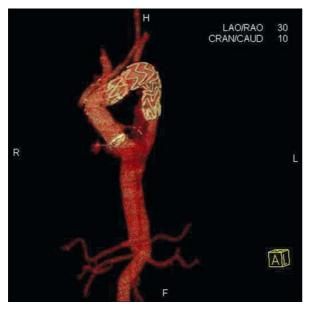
Computed tomography scan showing results of the second stage of treatment. It was made one day after a stent-graft implantation to the thoracic aorta. Metal struts of the stent-graft can be seen
